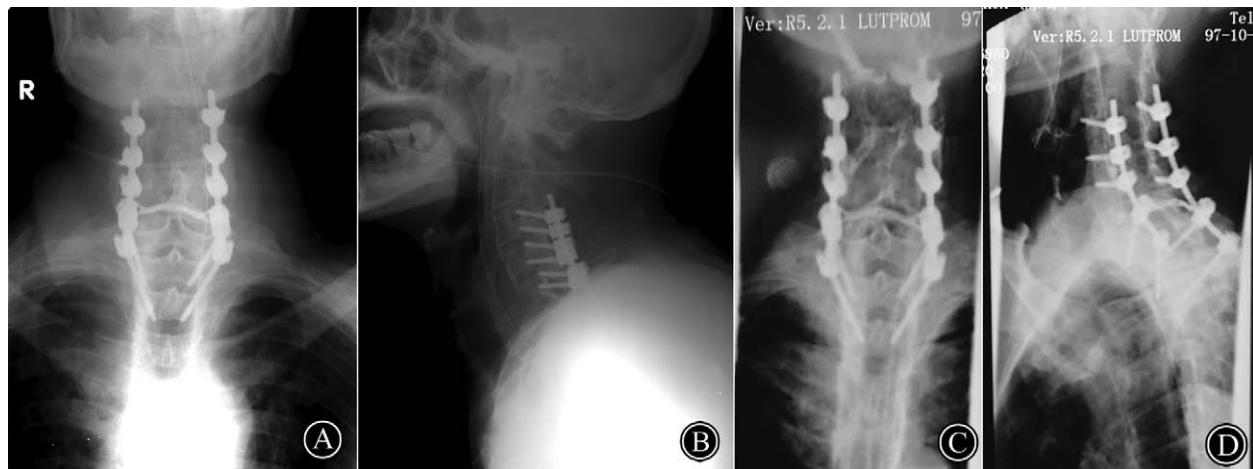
A and B, Postoperative anteroposterior and lateral radiographs revealed satisfactory reduction and fixation of the fracture. C and D, Union of the fracture and segmental stability of cervical spine was confirmed radiologically at 1-year follow up.
